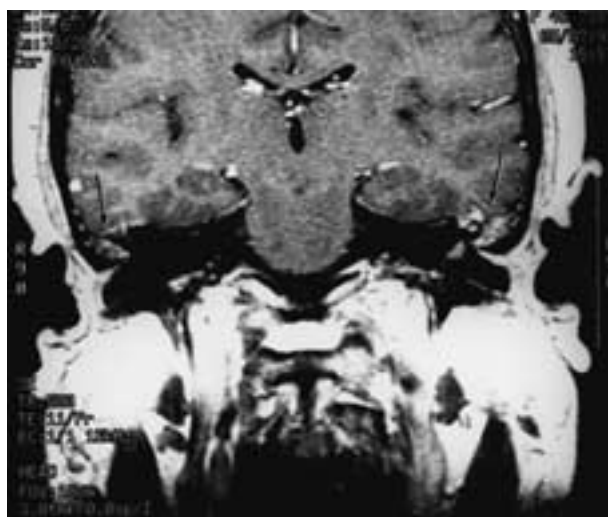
Bilateral granulation tissue. Coronal contrast-enhanced, T1-weighted image demonstrates enhancing debris bilaterally (arrows). CT revealed a diffuse, non-space-occupying abnormality without alteration and the contour of the TM.
